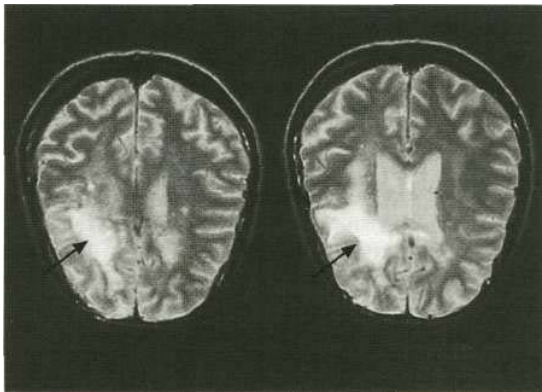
MRI scans showing progressive multifocal leucoencephalopathy.
